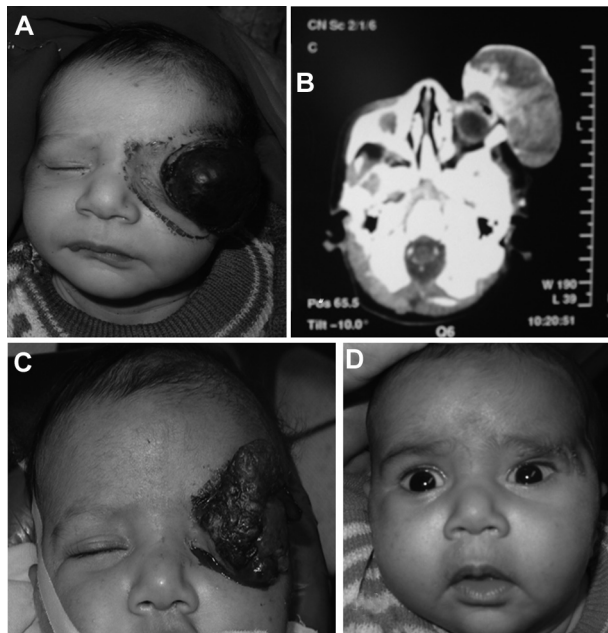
(A) Two-month-old boy presenting with a huge “tennis ball” hemangioma with (B) computed tomography scan showing no orbital extension. (C) Three days after parenteral steroids showing a marked decrease in size with sloughing of the overlying skin. (D) Two weeks after surgical removal.
